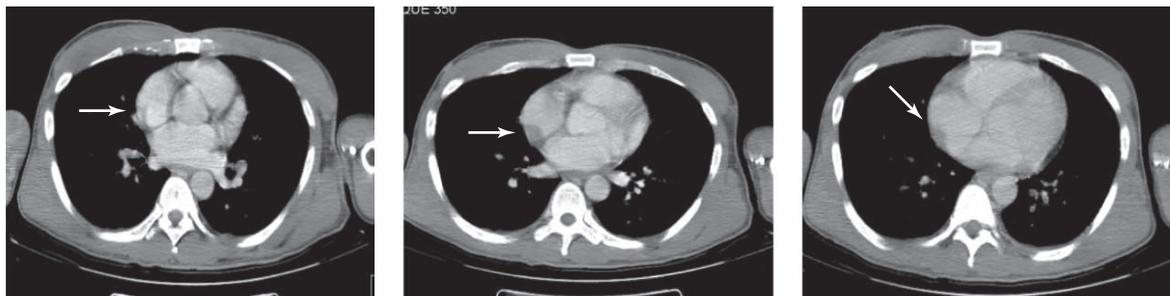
A contrast-enhanced computed tomography scan of the chest shows a filling defect in the right atrium measuring 2.2×2.1 cm in the transverse section invading the atrial wall. www.medreviews.com
